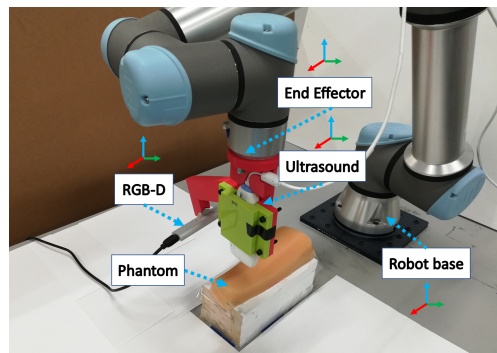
System Setup: Labelled frames of RGB-D camera, ultrasound probe, UR5 robot base frame and end-effector.
